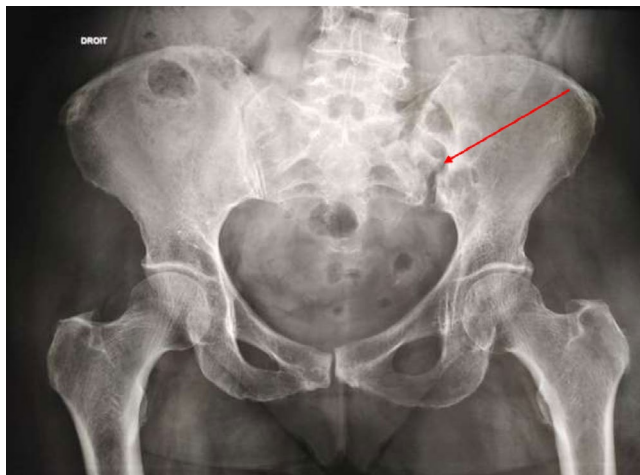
Plain radiograph of the pelvis showed widening of the left sacroiliac joint space with erosions of the subchondral bone
